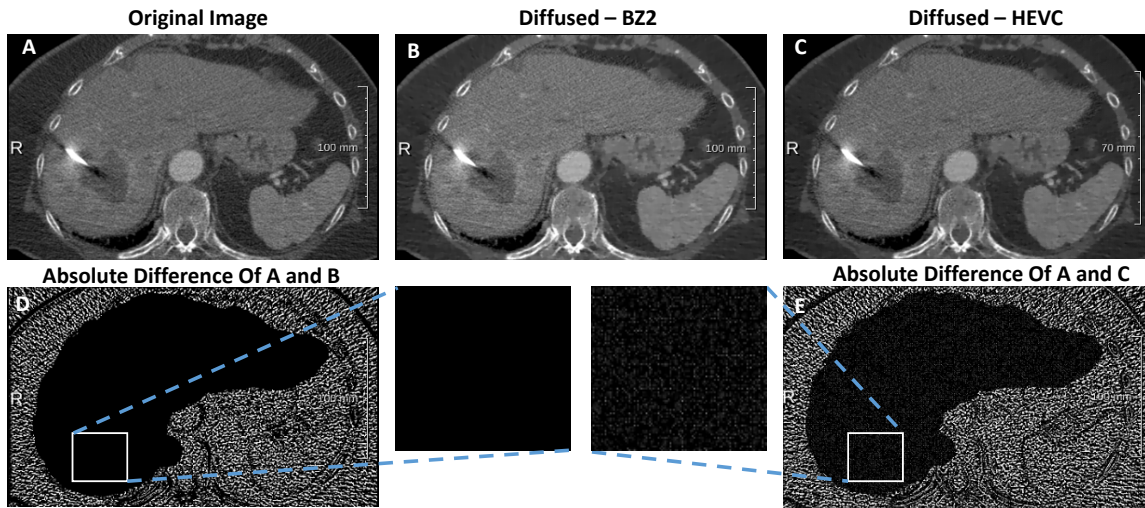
Examples of the decompressed CT images in RFA liver intervention using BZ2 and HEVC method.
